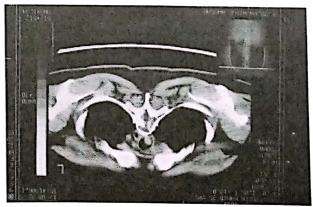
HRCT scan of chest
